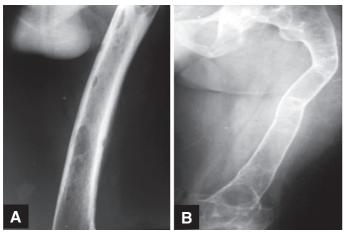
Hyperparathyroidism: Cystic Fibrous Osteitis. A. Tibia appearance on X-ray; where deformities, cystic lesions and sclerosis areas are seen; B. Gross tibial appearance, evidencing multiple cysts interposed by dense areas.
